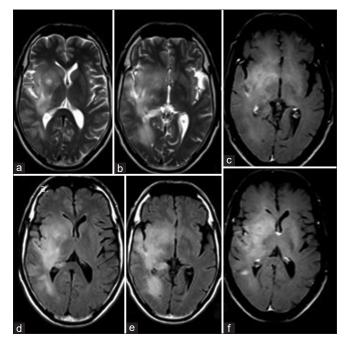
Sequential axial T2-weighted (a and b), FLAIR (d and e) and post-contrast T1-weighted (c and f) MRI done after 6 months showing an increase in the area of involvement of the abnormal high signal intensity in the right temporal lobe, right basal ganglion extending along the right occipital lobe. There is a mass effect on the right lateral ventricle FLAIR = Fluid-attenuated inversion recovery; MRI = Magnetic resonance imaging
